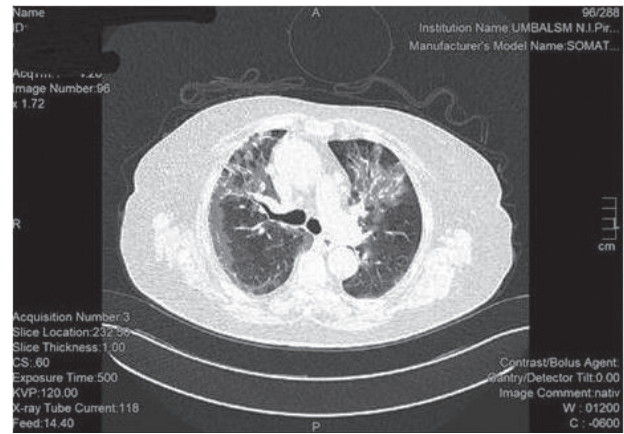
CT data for atypical pneumonia with viral genesis with moderately severe involvement 50–75% (patient with CLL).
